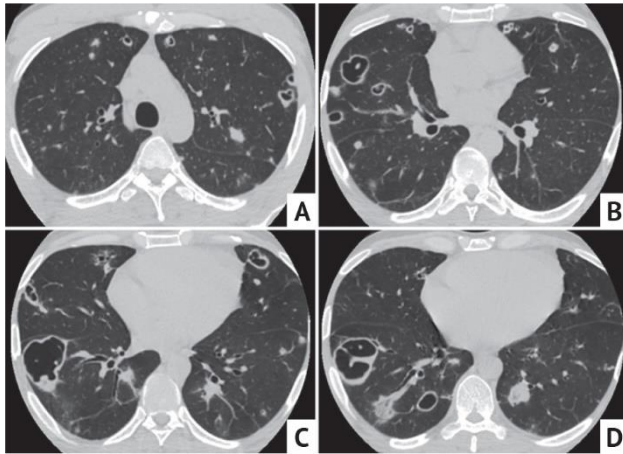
Axial chest CT images (A–D) of a 38 y.o. drug user with IE of the TV. Typical SPE. Thin-walled and different sized cavities in both lungs without pus and other pathological contents, and without infiltration around the cavities
